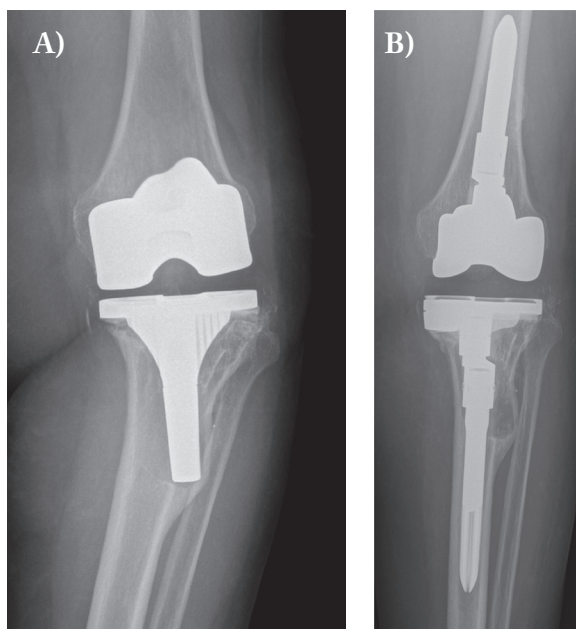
A) X-rays show TKA with aseptic loosening; B) X-rays after revision implant
